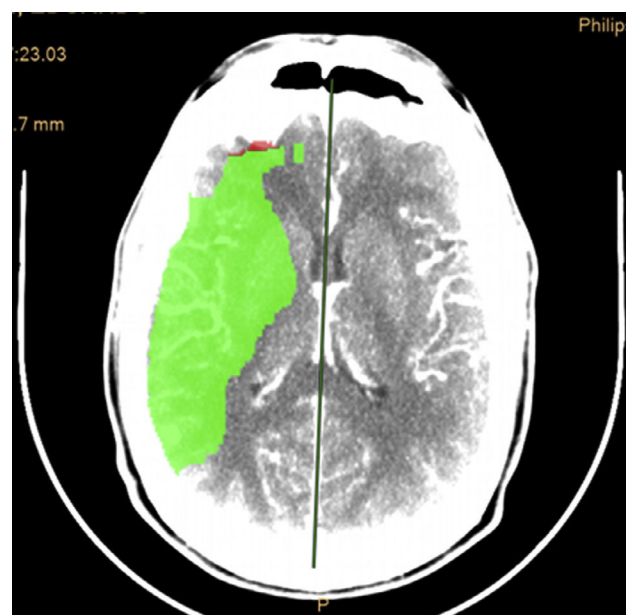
CT angiography of brain. Abnormal perfusion in the territory of the left middle cerebral artery corresponding to penumbra, without infarct zone.
